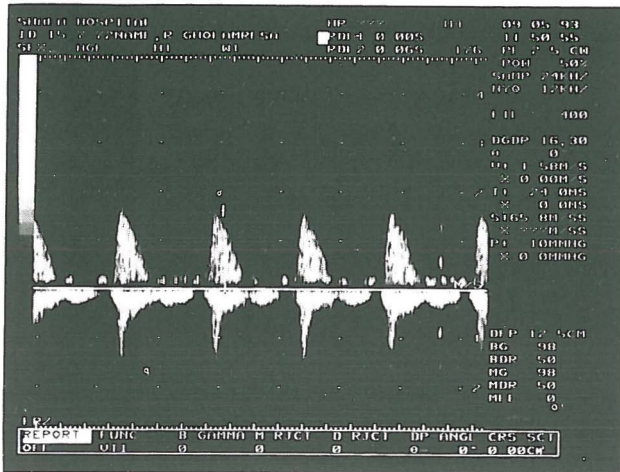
Doppler echo study of aortic valve flow.
